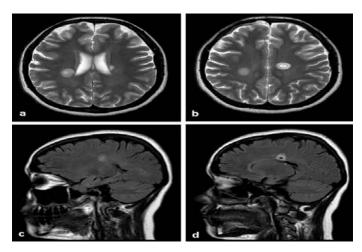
Axial T2-weighted (a, b) and sagittal FLAIR (c, d) images demonstrate a right frontoparietal (a, c), and a callosal (b, d) lesion which show a concentric lamellar appearance, consistent with Balo's concentric sclerosis.
